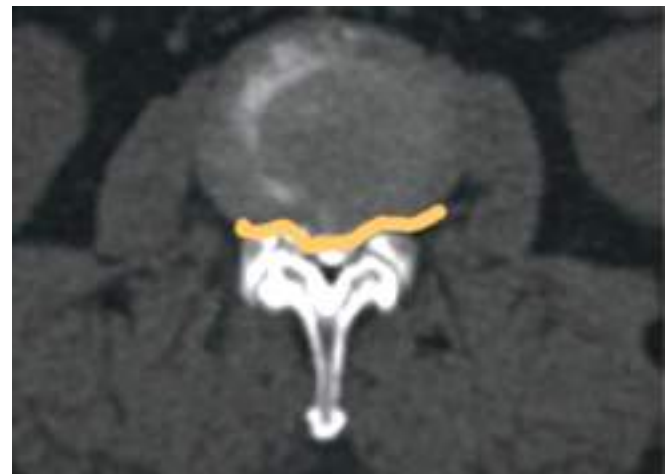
CT image showing smooth circular extension of the annulus beyond the vertebral endplate suggestive of a disc bulge
